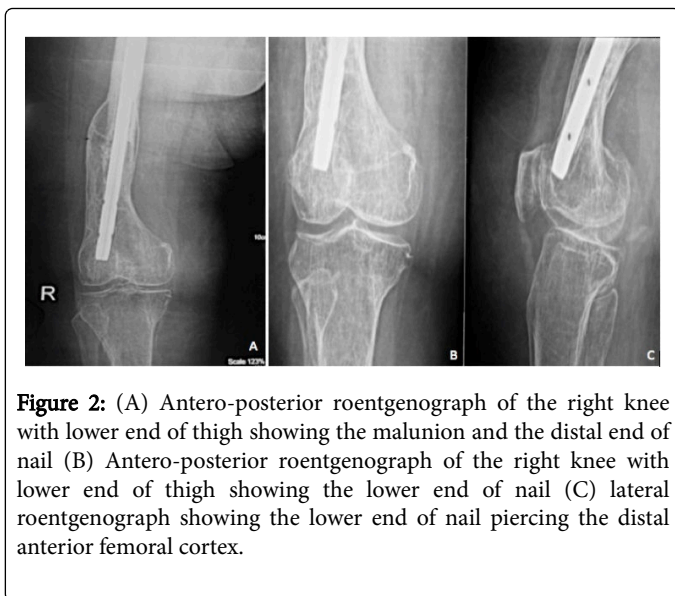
(A) Antero-posterior roentgenograph of the right knee with lower end of thigh showing the malunion and the distal end of nail (B) Antero-posterior roentgenograph of the right knee with lower end of thigh showing the lower end of nail (C) lateral roentgenograph showing the lower end of nail piercing the distal anterior femoral cortex.
